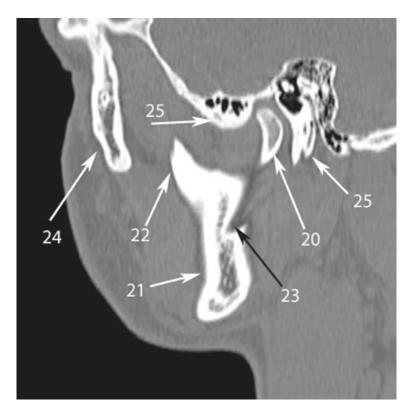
Sagittal CT scan at the level of mandibular foramen. *Numbers* with *arrows* denote the following anatomical structures: 20 – mandibular condyle; 21 – ramus of the mandible; 22 – coronoid process; 23 – the beginning of the mandibular conal (near the mandibular foramen); 24 – zygomatic bone; 25 – temporal bone.
